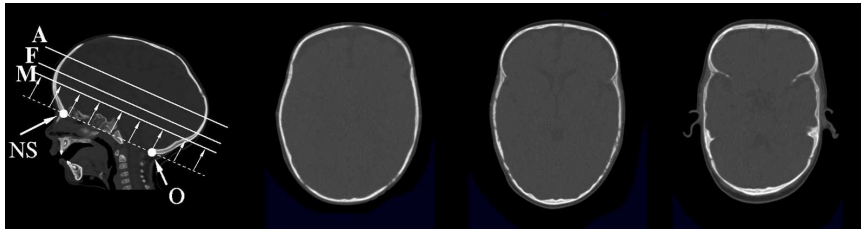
All shape descriptors are constructed using the CT image slices extracted from skull imaging. These bone slides are defined by selecting the base plane on the 3-D image and finding internal anatomical landmarks on cerebral ventricles.
